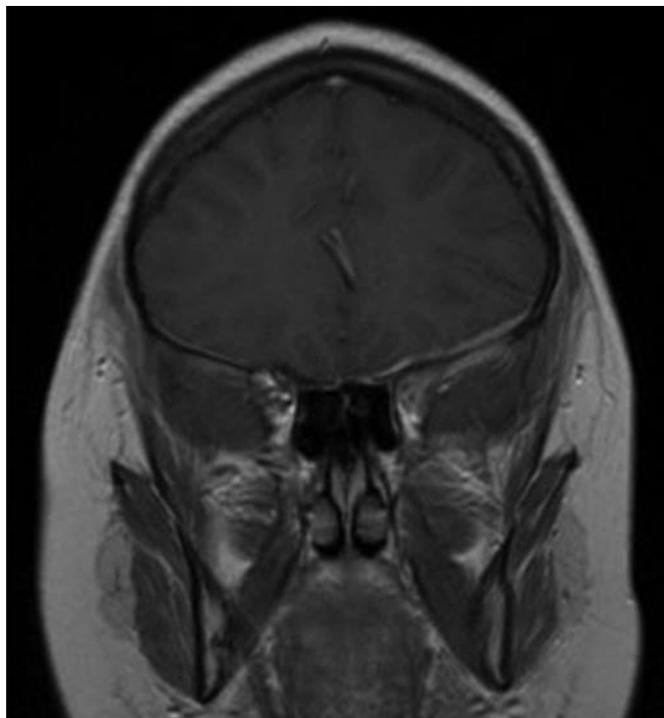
MR image of the head showing complete resolution of parenchymal signal abnormality within the left frontal lobe, with a new dural thickening and enhancement involving the inferior left frontal skull base. There is also a proptotic left globe, with new left orbital enhancing inflammatory change, in continuity with the intracranial left frontal dural disease.
